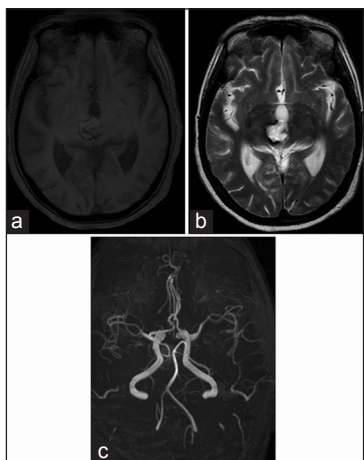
Magnetic resonance imaging of brain done after about one month showing T1 (a), T2 (b) resolving hematoma. Magnetic resonance angiogram (c) showing no abnormality in vertebral and basilar arteries
